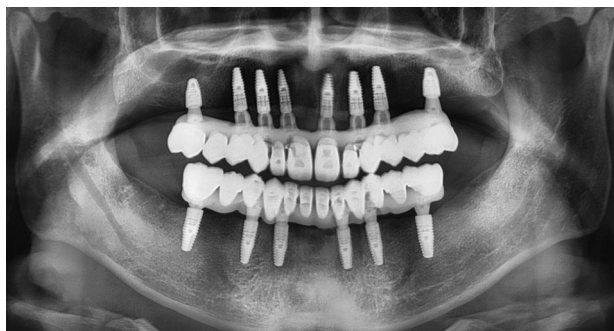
Panoramic radiograph after definitive restoration delivery.
